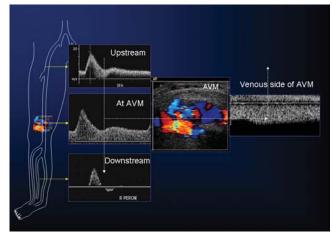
Effect of AVM on spectral Doppler waveforms. In the lower extremity upstream waveforms in the femoral artery demonstrate high velocity low resistance flows. High velocity, low resistance, and turbulence are found at the site of the AVM. Downstream from the AVM, high-resistance triphasic flows resume. Venous outflow of the AVM is hyperdynamic and may be pulsatile.
